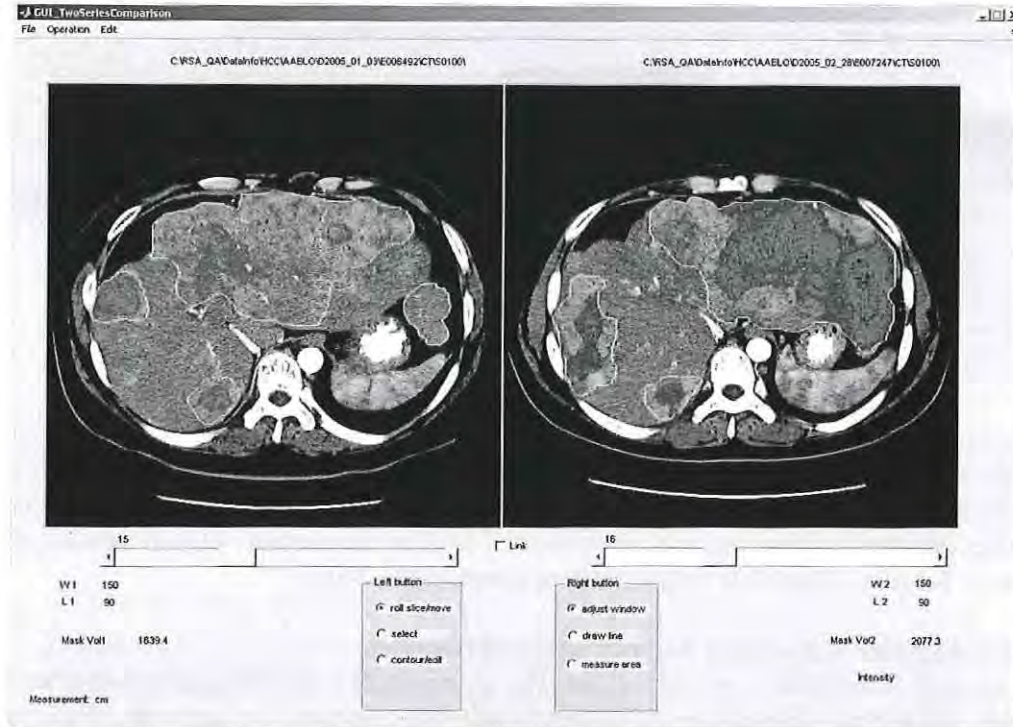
An image processing system allows manual segmentation of liver tumor (with blue border) and tumor necrosis (area in red). Segmented tumor contours and necrosis areas are superimposed on baseline (left) and follow-up (right) CT images. Tumor volume increased 29.5%, whereas ratio of tumor necrosis volume to tumor volume increased 388.8%.
